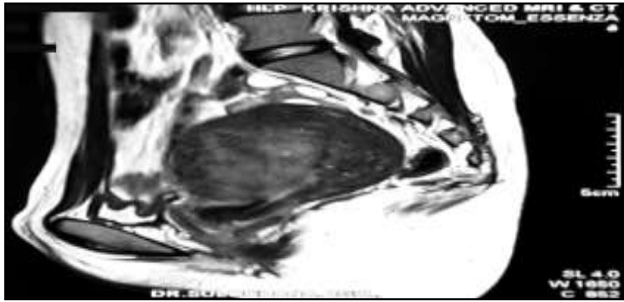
MRI sagittal section showing a large lesion with mixed intensity seen within the endometrium, extending predominantly into the anterior myometrium with loss of endometrial interface.
